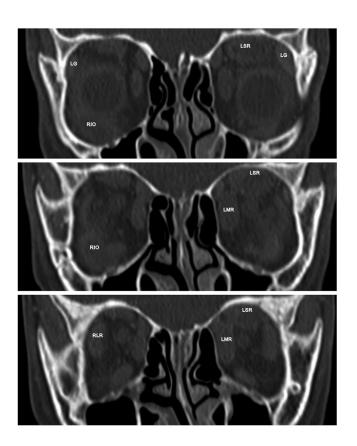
Computed tomography, coronal cuts from anterior (top) to posterior (bottom) demonstrating enlargement of the right inferior oblique (*RIO*), right lateral rectus (*RLR*), left superior rectus (*LSR*), left medial rectus (*LMR*) muscles, and bilateral lacrimal glands (*LG*).
